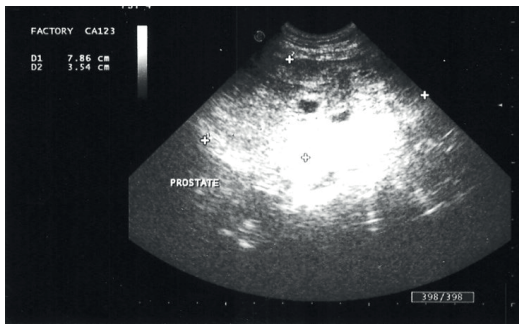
Prostate ultrasound for a patient with multiple intra and paraprostatic cysts (FMVB)
